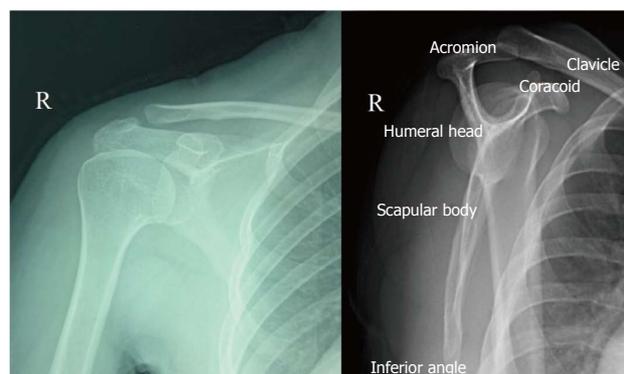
Anteroposterior shoulder view and scapular Y view radiographs.
